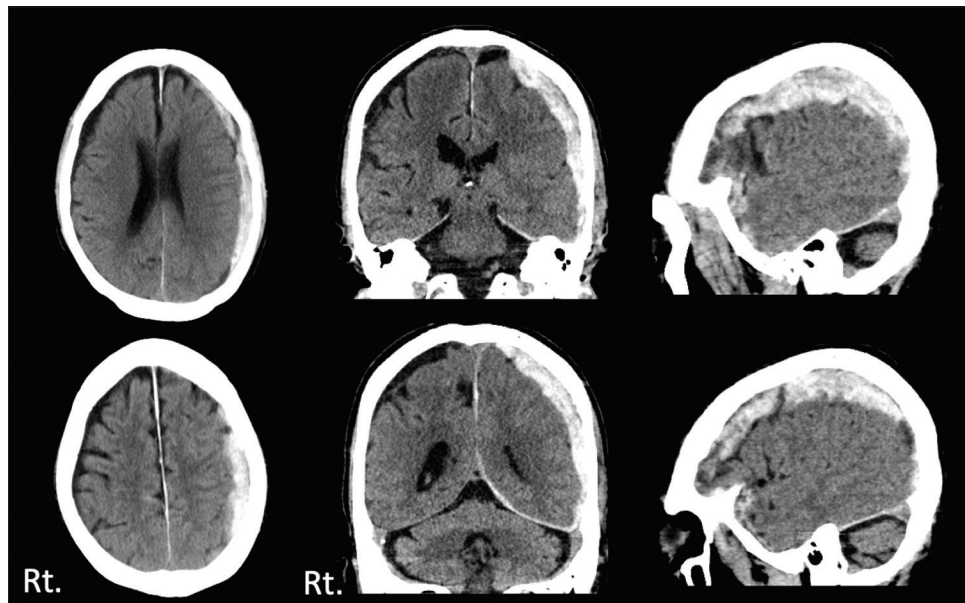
Head computed tomography on day 3 after head injury; it was appeared that left acute subdural hematoma with mass effect.
